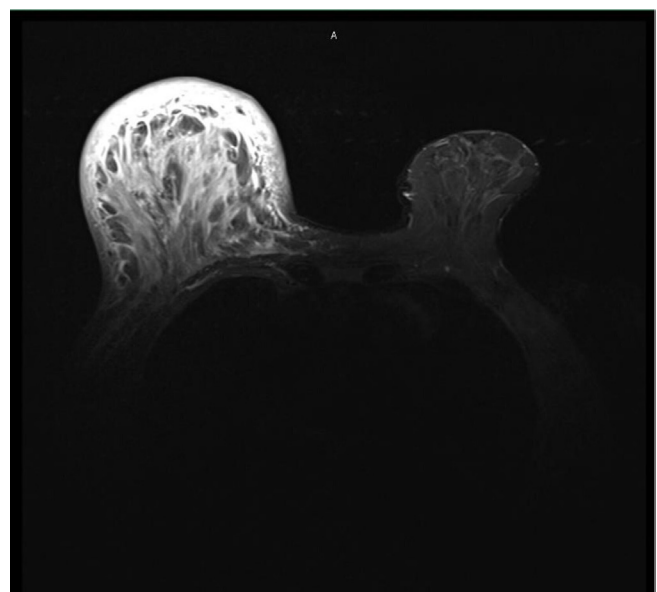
Breast magnetic resonance imaging showed asymmetrical breast size, the right breast was larger than the left one and displayed a diffuse homogeneous parenchymal enhancement with diffuse trabecular and skin edema, no suspicious mass
